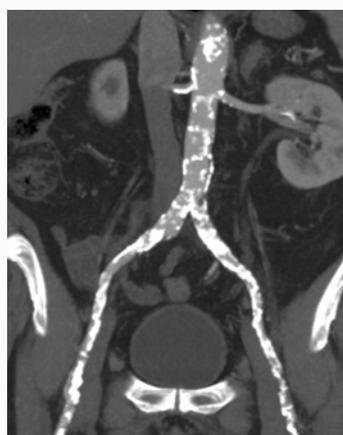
CT scan demonstrates the multiple occlusions and stenosis at left iliac and common femoral arteries.
